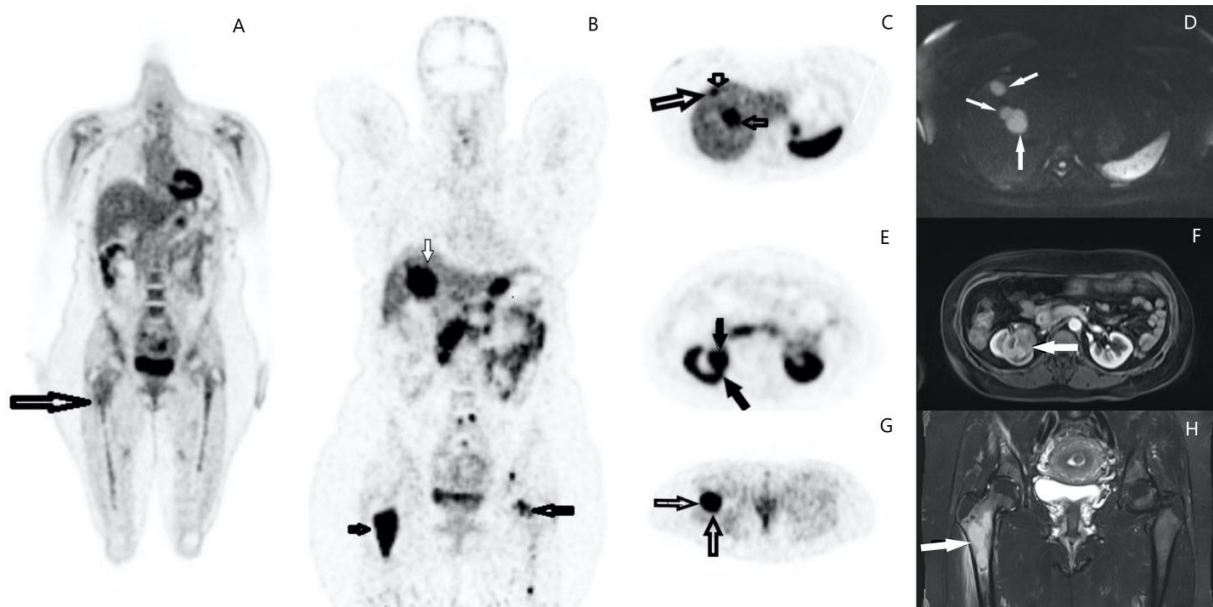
Tumoral masses in the liver, right renal cystic metastasis, and most of the bone metastasis are negative in FDG PET (A) and positive in ^{68}Ga -DOTATATE PET (B). 2 Liver lesions in VIII segment showing intense ^{68}Ga -DOTATATE uptake in axial Ga DOTATATE PET MIP image (C) and strongly restricted diffusion in diffusion-weighted axial MRI (D). Contrast-enhanced axial T1A FS MRI (F) images and axial MIP DOTA PET images (E) demonstrate a right renal cystic metastatic lesion with a great avidity for ^{68}Ga -DOTATATE. The largest bone metastasis is located in the right femoral neck, causing surrounding soft tissue edema and cortical thinning; coronal T2A FS MRI (H). Intramedullary tumor showing metabolic activity both in FDG-PET/CT (A) and ^{68}Ga -DOTATATE PET/CT (B, G)
